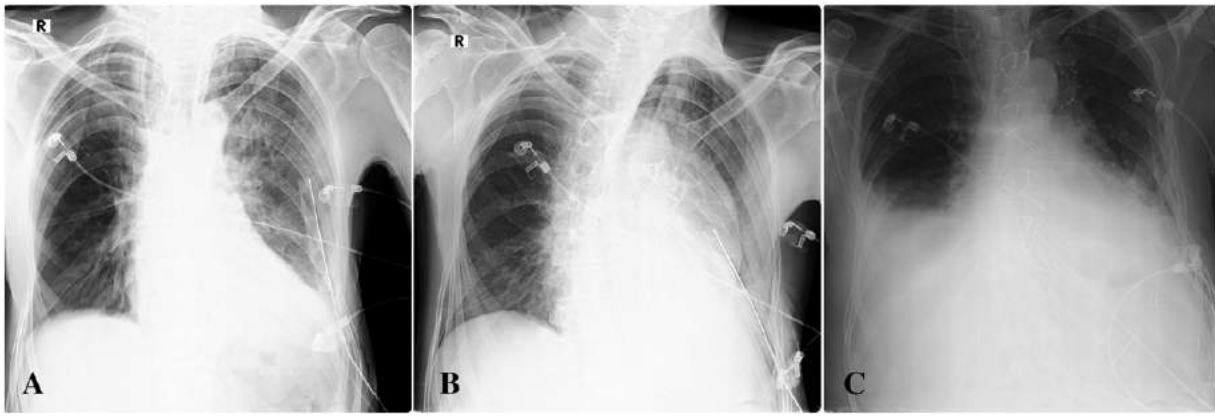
Chest roentgenogram (A) Early postoperative (B) Cardiac tamponade (C) After reopening.
